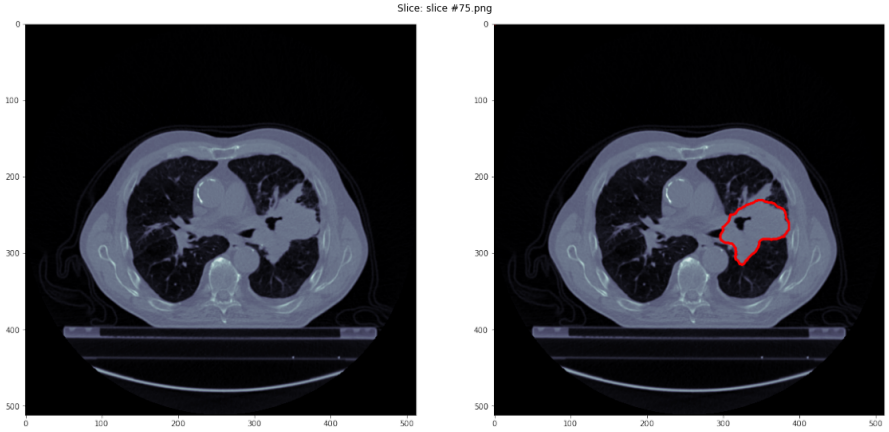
Example of the quick check of the segmentation alignment to the original scan by visualizing CT axial slices.
